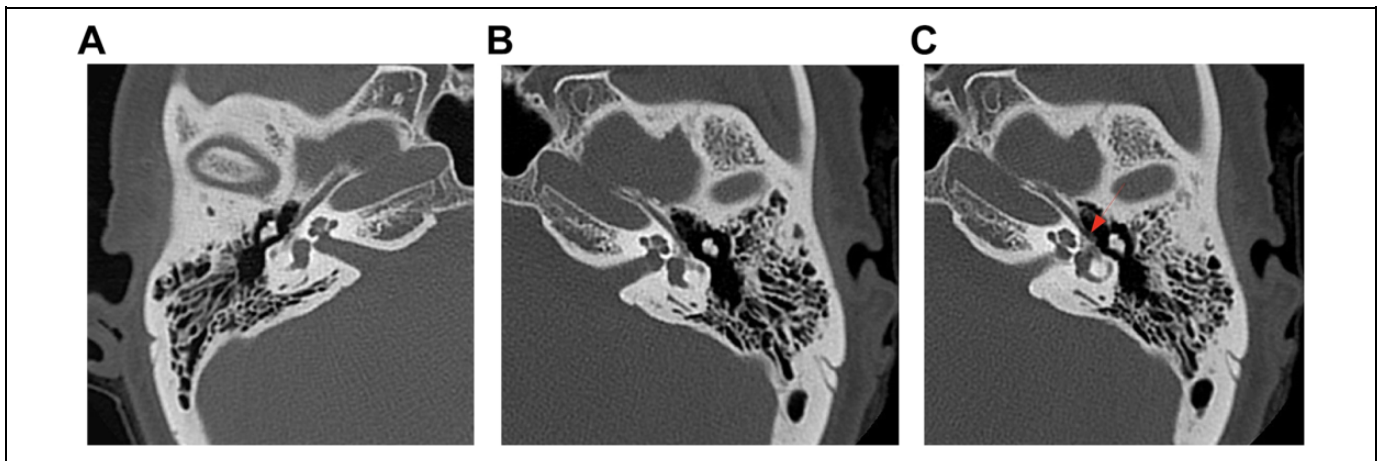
High-resolution computed tomography scan of the temporal bone with bone algorithm of right (A) and left (B, C) petrous and mastoid bone. In both sides, bilateral morphology of the internal ear and in particular of the cochlea and internal auditory canal is apparently normal. A left fenestral otospongiotic area is evident (red arrow).
